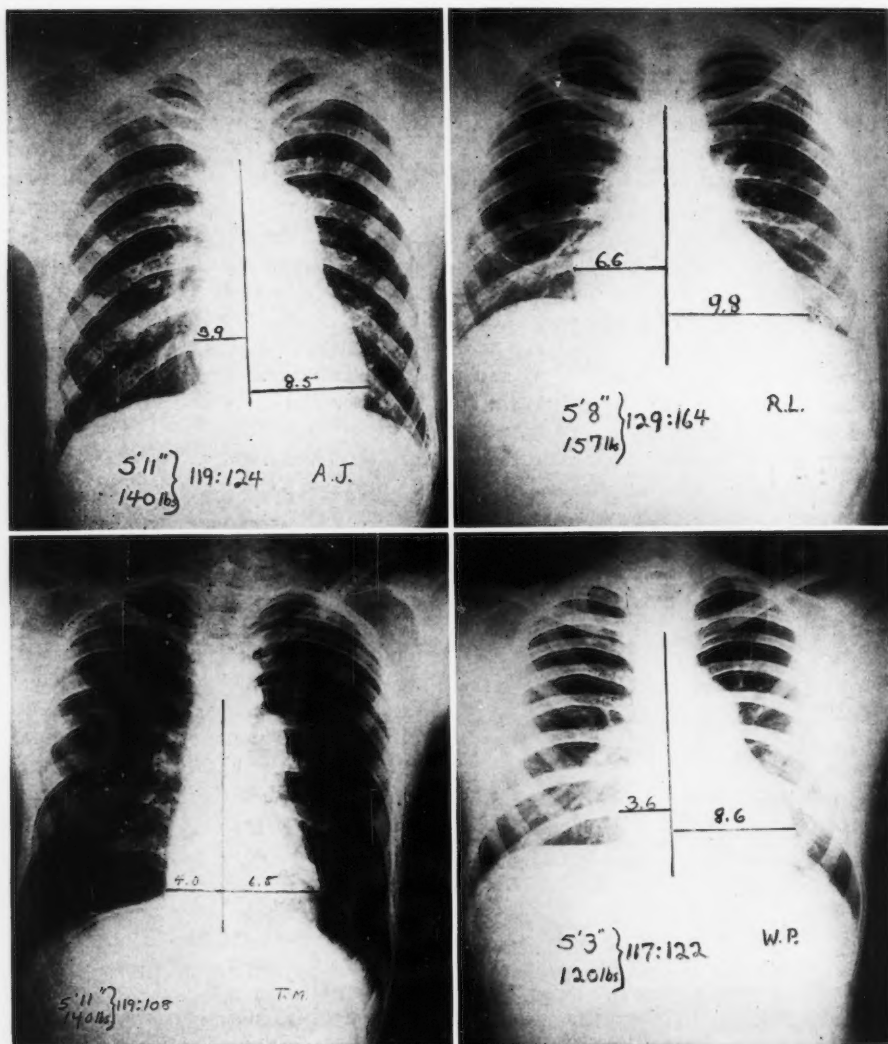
PA Roentgenograms of Cases 1 (upper left), 2 (upper right), 4 (lower left), and 6 (lower right). Note the prominent pulmonary artery and normal pulmonary vascular markings in each.
